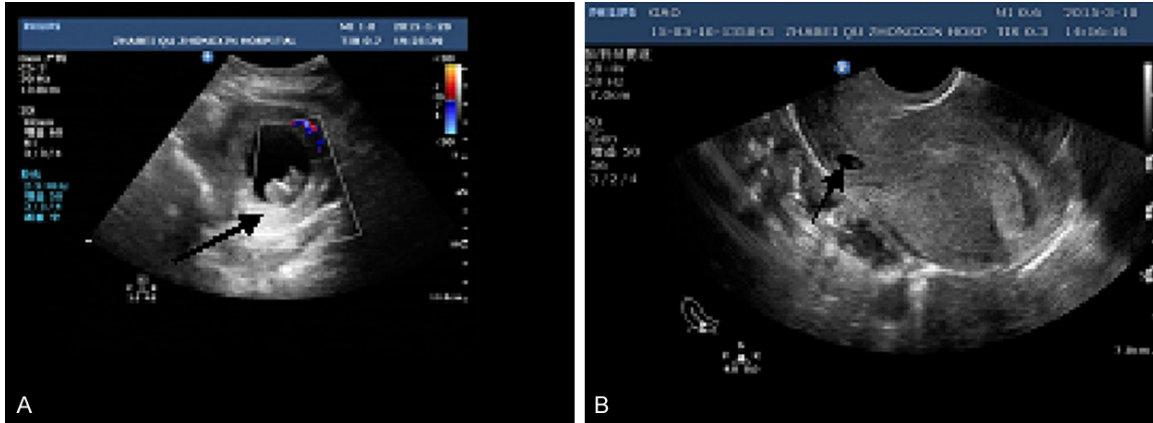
A. Ultrasonography showed the gestational sac implanted in the scar that grew toward the urinary bladder (arrow indicated). B. Ultrasonography showed the gestational sac implanted in the scar that grew toward the uterine cavity (arrow indicated).
